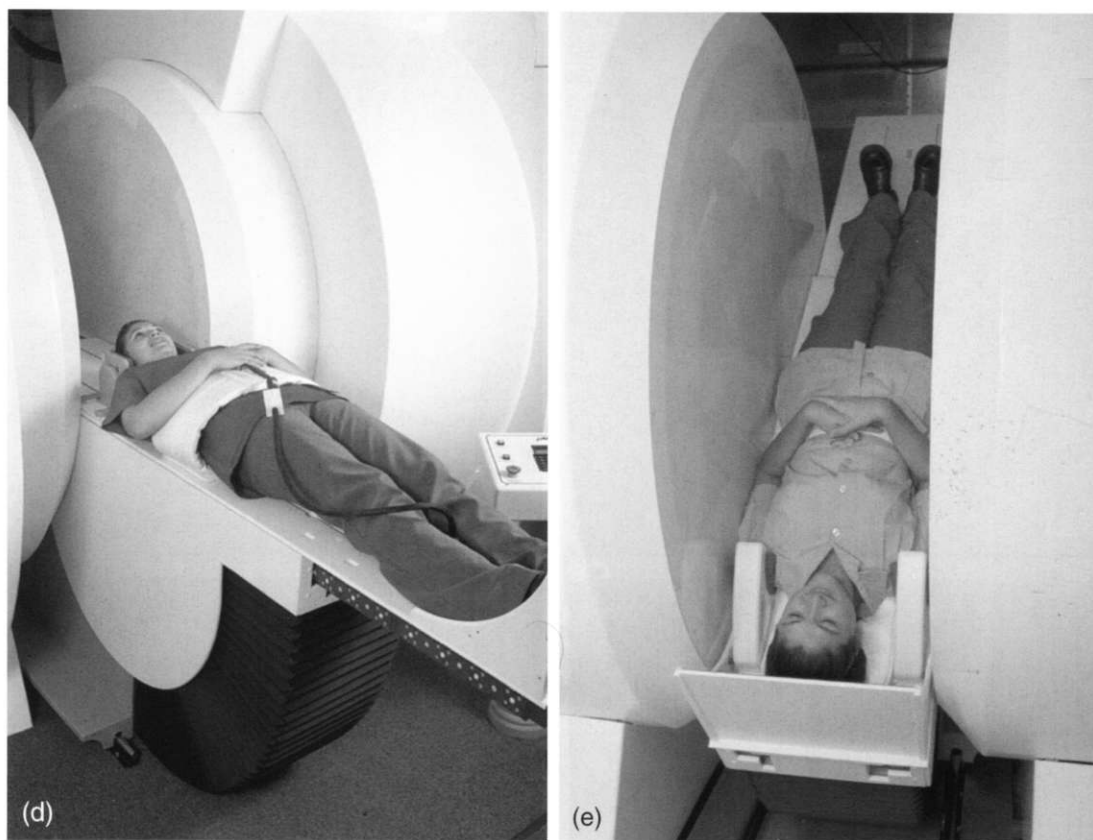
Various patient/table configurations of the 'Stand Up™' MRI unit. (a) Patient standing in unit (standing-neutral pMRI). (b) Patient in lateral bending maneuver (lateral bending kMRI). (c) Patient in lumbar flexion maneuver (flexion kMRI). (d) Patient in recumbent position (rMRI). (e) Patient in Trendelenberg position (negative angled pMRI).
